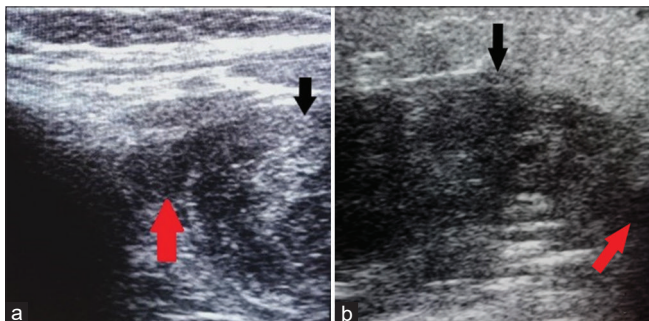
(a and b) Ultrasound well-defined, encapsulated (black arrow), ovoid heterogeneously hypoechoic space-occupying lesion within the muscle plane, with a hypoechoic extension (red arrow)
